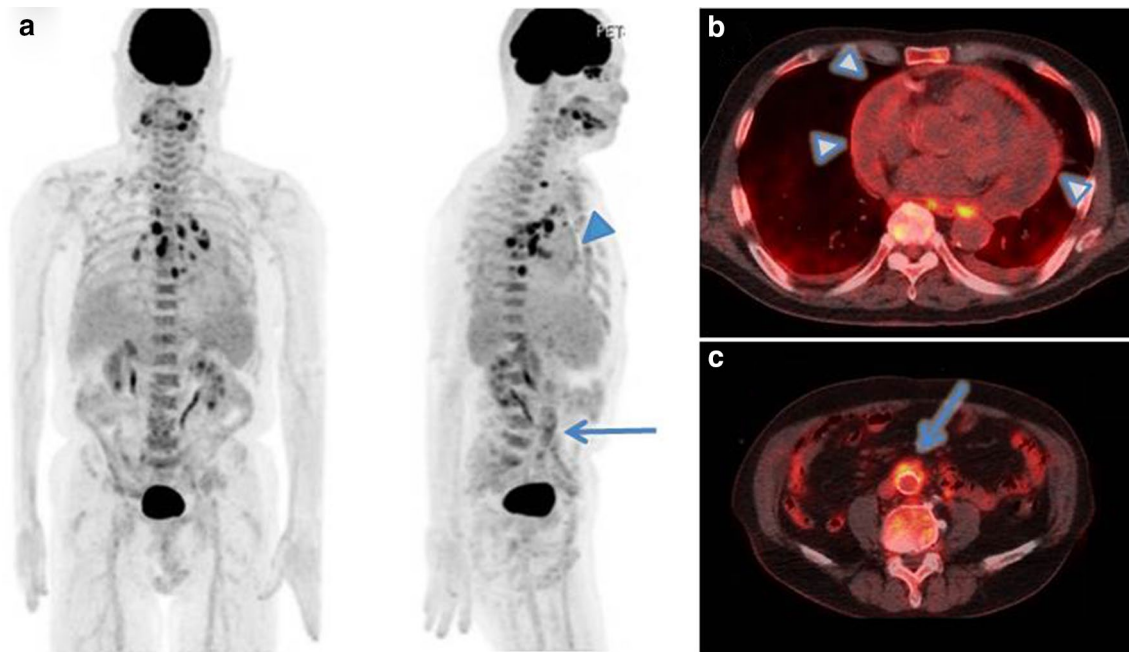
^{18}F -FDG-PET/CT. ^{18}F -FDG-PET. Increased uptake was observed in the mediastinal lymph node, pericardium (*arrowheads*), and abdominal aorta (*arrows*)
